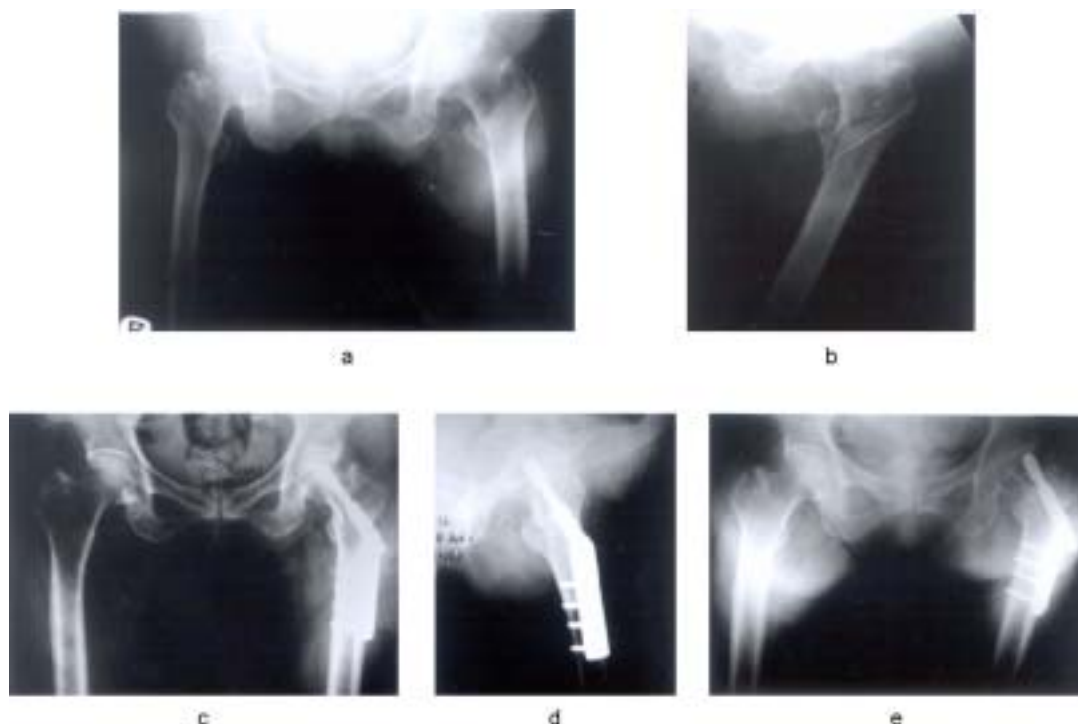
A 82-year-old female with intertrochanteric fracture on her left hip. a, b: Preoperative AP and lateral x-ray shows an unstable fracture without medial support. c, d: AP diastasis is 9 mm, postoperative displacement of lesser trochanter is 0 mm, position of lag screw is superior position and TAD is 30 mm in postoperative AP and lateral x-ray. e: Ten months after surgery, the AP x-ray shows union failure with cutting out of the lag screw. Sliding of lag screw is 12 mm and the neck shaft angle is 110°.
